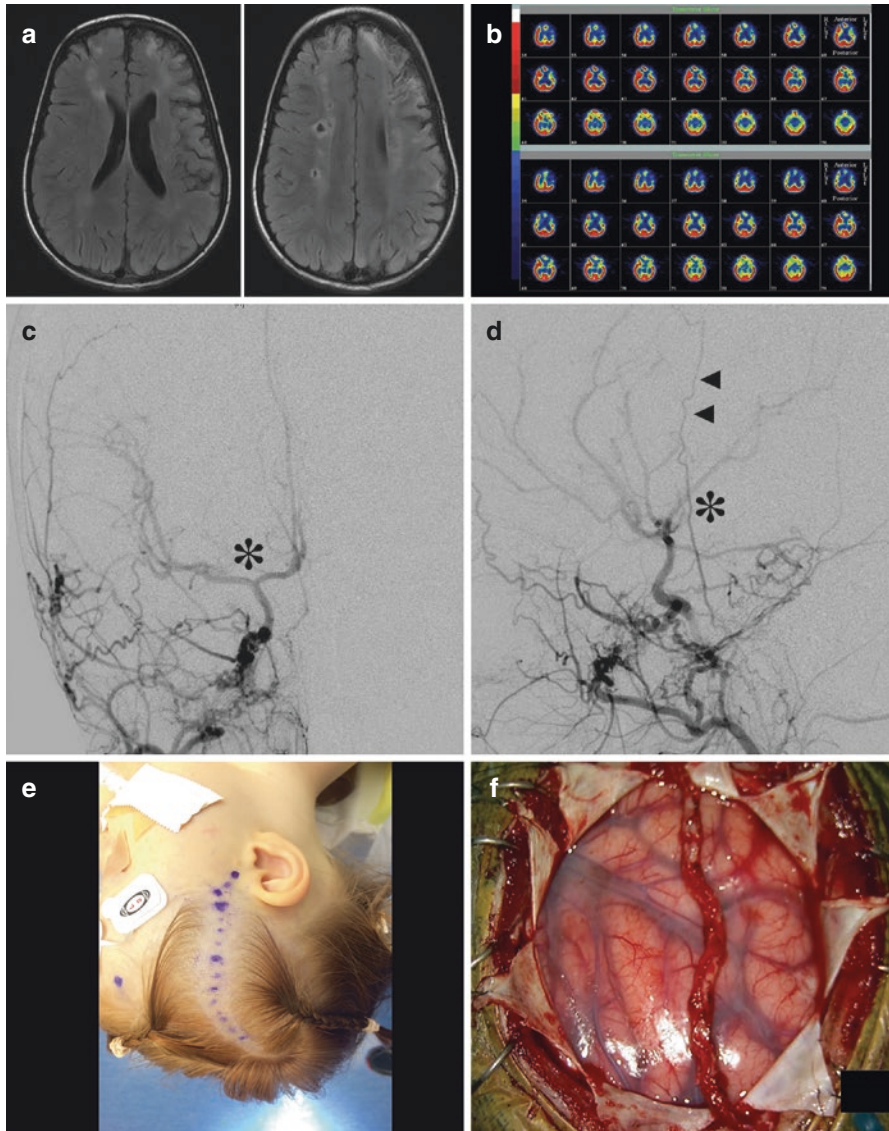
A 6-year-old patient presented with intermittent episodes of speech disturbance and walking difficulty. (a) MRI brain (FLAIR) showing evidence of bilateral watershed ischemia. (b) Technetium-99 scan showing a bifrontal perfusion defect, worse on the left, with a Diamox induced steal phenomenon on the right frontal area in keeping with impaired cerebrovascular reserve. (c, d) Right CCA injection (AP & lateral views) showing moderate right supraclinoid ICA stenosis (*asterisk*) and a very thin right STA (*arrowheads*) branch for revascularization. (e, f) Intraoperative view of right EDAS, with a cuff of soft tissue left around the right STA branch, and laid on the exposed brain parenchyma, after stellate dural opening. (g, h) Right CCA injection (AP & lateral views) at 9 months post right EDAS showing progressive disease of the right supraclinoid ICA stenosis (*asterisk*), and indirect collateralization from the EDAS (*arrowhead*). (i, j) Left ICA injection (AP & lateral views) showing occlusion of the distal left ICA (*arrows*) with moyamoya collateralization resembling a “puff of smoke” (*block arrows*). (k, l) Left CCA injection (AP & lateral views) at 9 months post left EDAMS showing extensive collateralization supplying MCA territories (*block arrowheads*). She remained symptom free at 5 years follow-up
